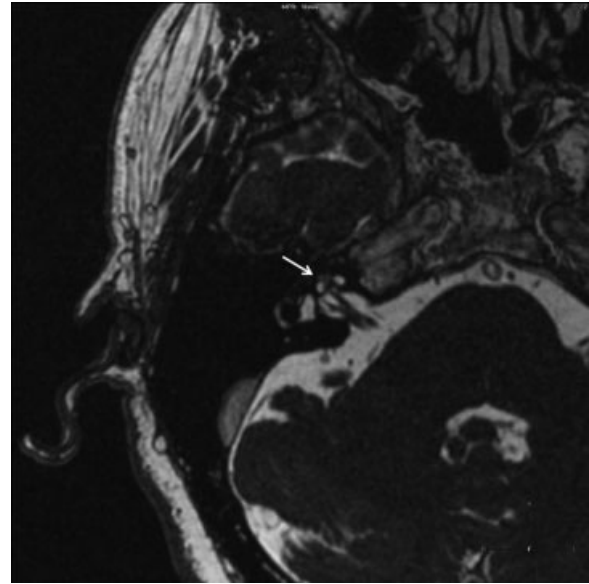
Axial T2-weighted magnetic resonance image of the inner ear showing an intracochlear schwannoma as a hypointense mass that has replaced the normal fluid of the right cochlea (arrow).
